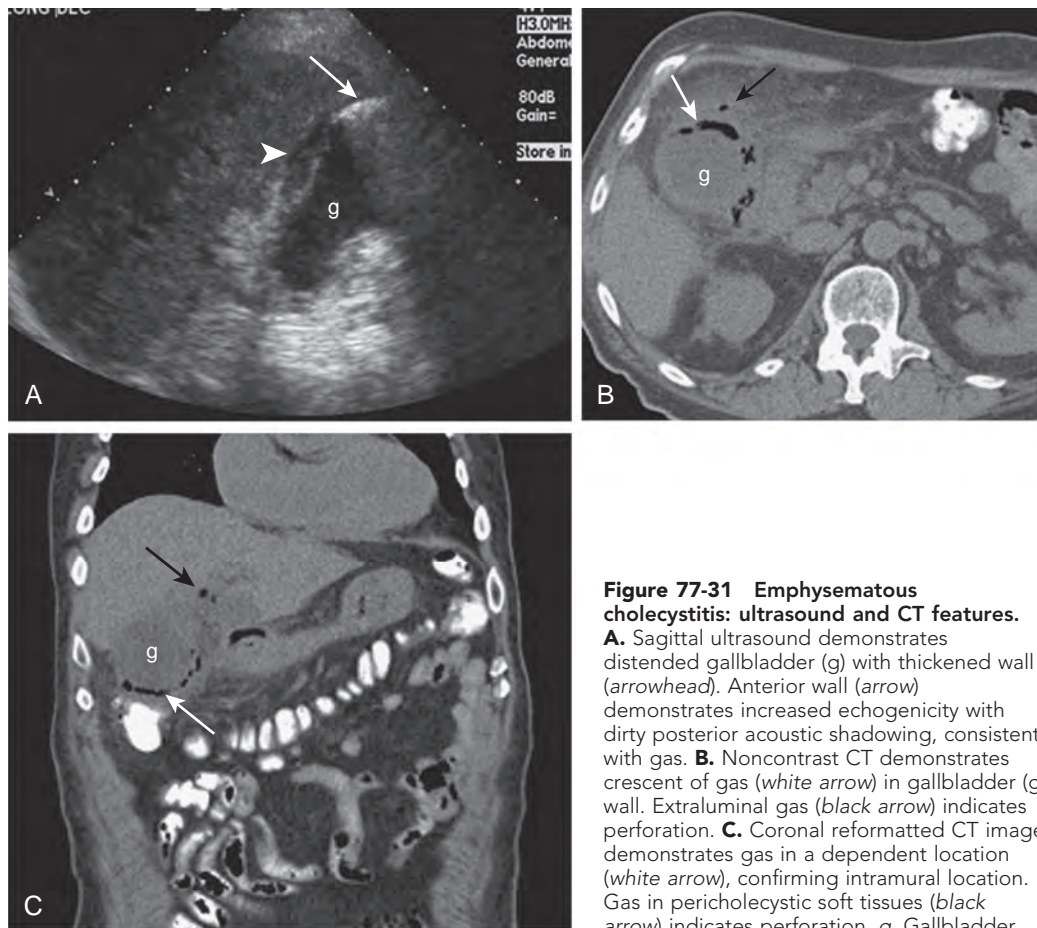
Emphysematous cholecystitis: ultrasound and CT features.
